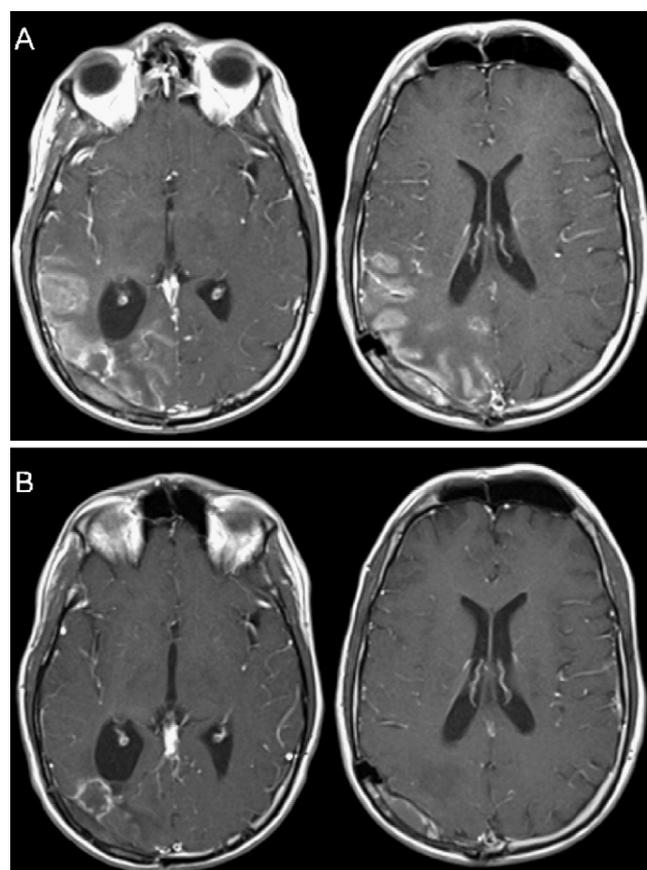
Case 1: A 31-year-old man with right occipital glioma status after resection. A: Axial T1 contrast-enhanced MRI scans obtained at time of seizures. Note the abnormal gyriform and meningeal enhancement in the right occipital and posterior temporal lobes thought to be related to seizure-induced hyperperfusion and vascular leak. B: Axial T1 contrast-enhanced postictal MRI scans obtained 11 days after seizure control. The abnormal gyriform and meningeal enhancement seen in the earlier images has resolved completely. Residual linear ring enhancement is seen along the occipital lobe resection cavity, a stable finding compared with previous MRI examinations.
